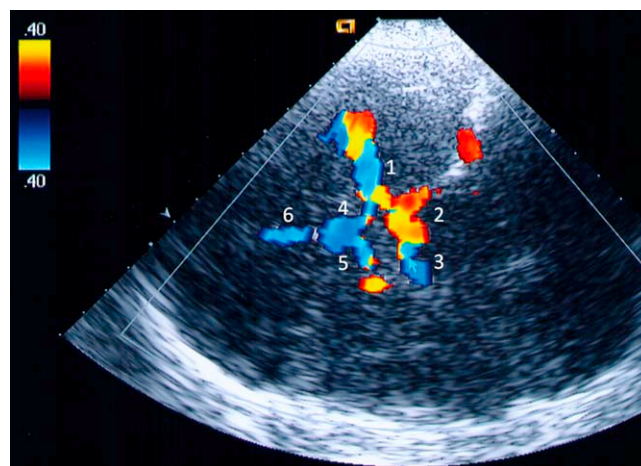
View of the basal cerebral arteries in the axial plane with transtemporal insonation. Color-coded duplex sonography of the ipsilateral middle cerebral artery (MCA)=1, ipsilateral posterior cerebral artery (PCA)=2, contralateral PCA=3, A1 segment of the ipsilateral anterior cerebral artery (ACA)=4, A1 segment of the contralateral ACA=5, and A2 segment of the ipsilateral and/or contralateral ACA=6. Due to insufficient resolution, a side differentiation of the A2 segments (of both sides) is not possible.
